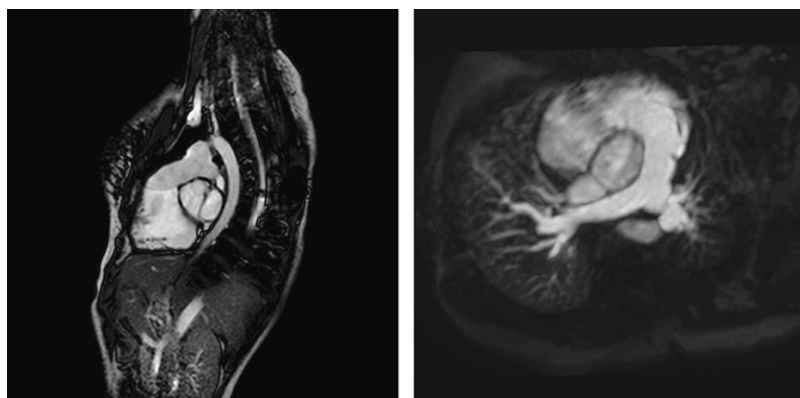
Magnetic resonance images showing competence of the bicuspid PTFE valve in the lateral view and no interference to flow in systole in the craniocaudal view. This valve has been inserted for dilatation the right ventricle after repair of pulmonary atresia and closure of ventricular septal defect 14 years previously.
